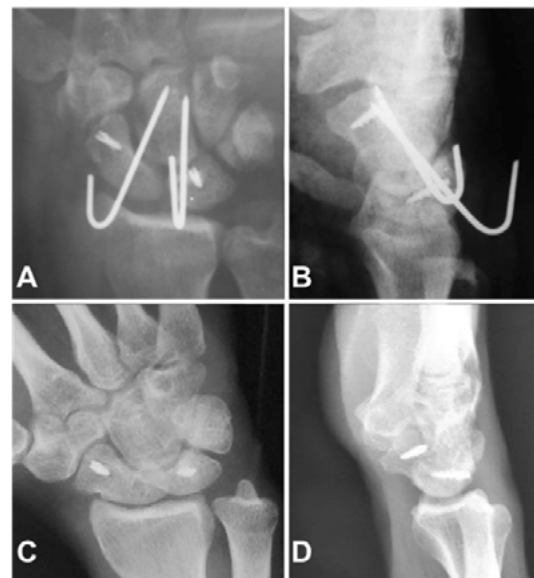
Immediate postoperative radiographs show restoration of carpal alignment (A and B). 24-months follow-up the imaging exams still demonstrate the maintenance of reduction (C and D). Source: Own elaboration.
